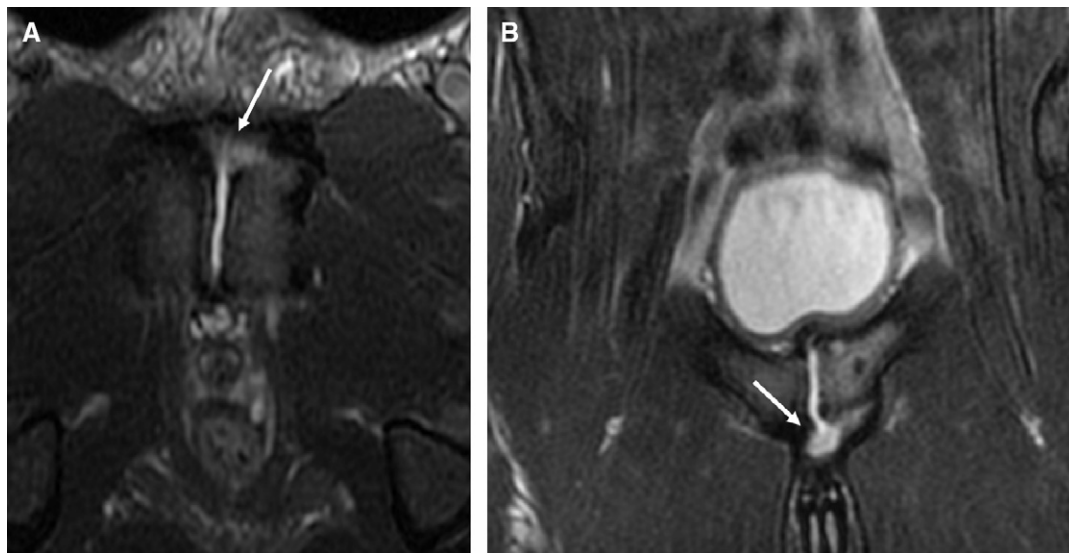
Secondary cleft sign. (A, B) Axial and coronal fat-saturation fast spin-echo T2-weighted magnetic resonance imaging, demonstrating abnormal pubic bone marrow oedema combined with an adjacent linear region of high T2 fluid signal (secondary cleft sign, arrow), which extended from the intra-articular primary cleft secondary to an aponeurotic complex injury and partial avulsion of left adductor longus origin. Findings were confirmed at the time of surgery, and the patient subsequently returned to professional soccer.
